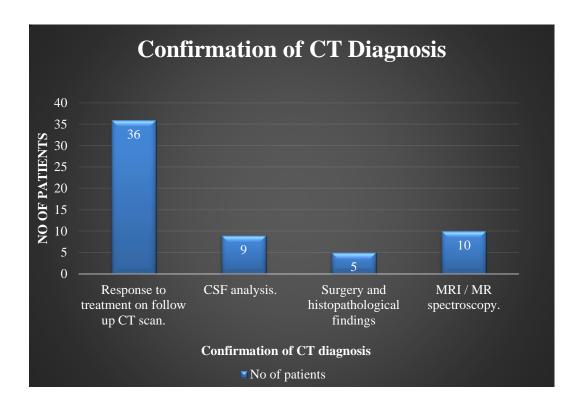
Confirmation of CT Diagnosis
